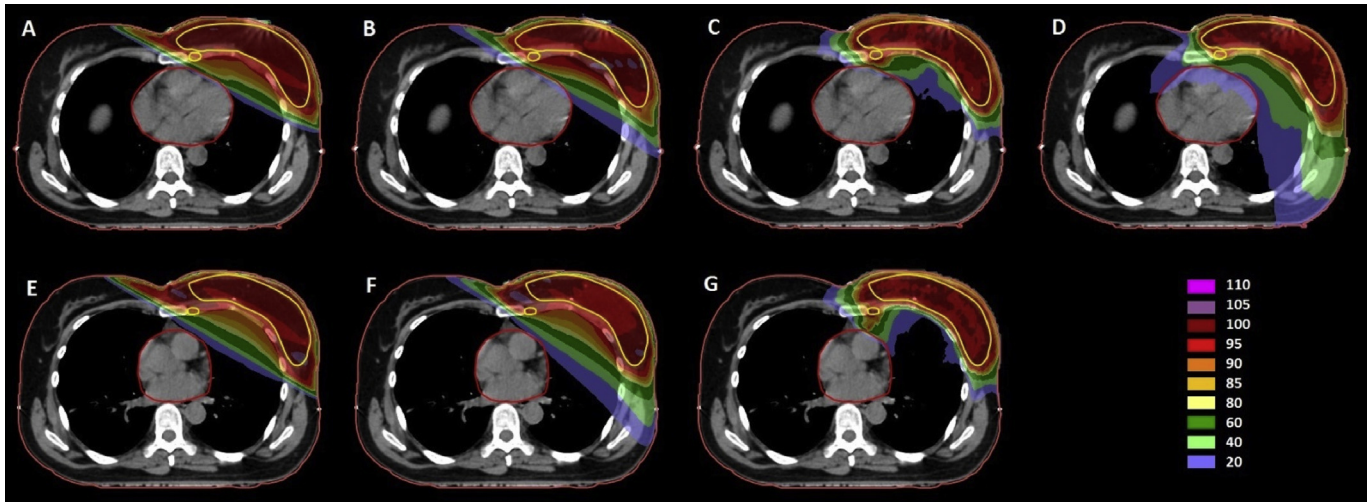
Images of the same computed tomography slice in the same patient showing the dose distribution achieved by each of the seven radiotherapy planning techniques. The top row displays free breathing plans: (A) wide tangents in free breathing (WT(FB)), (B) volumetric-modulated arc therapy in free breathing (VMAT(FB)), (C) proton beam therapy in free breathing (PBT(FB)), (D) tomotherapy in free breathing (tomotherapy(FB)). The bottom row displays breath-hold scans: (E) wide tangents in voluntary deep inspiratory breath-hold (WT(vDIBH)), (F) volumetric-modulated arc therapy in voluntary deep inspiratory breath-hold (VMAT(vDIBH)), (G) proton beam therapy in voluntary deep inspiratory breath-hold (PBT(vDIBH)). The structures outlined in yellow are the whole breast and internal mammary chain clinical target volumes.
